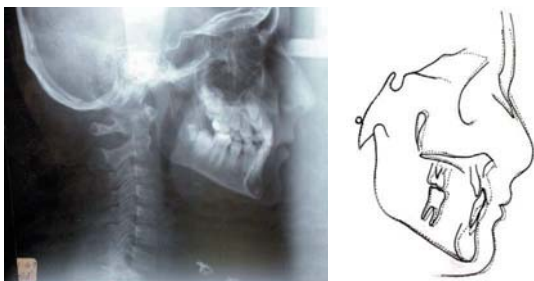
Post-treatment radiograph and pre-treatment (solid lines) and post-treatment (dashed lines) cephalometric superimposition.
